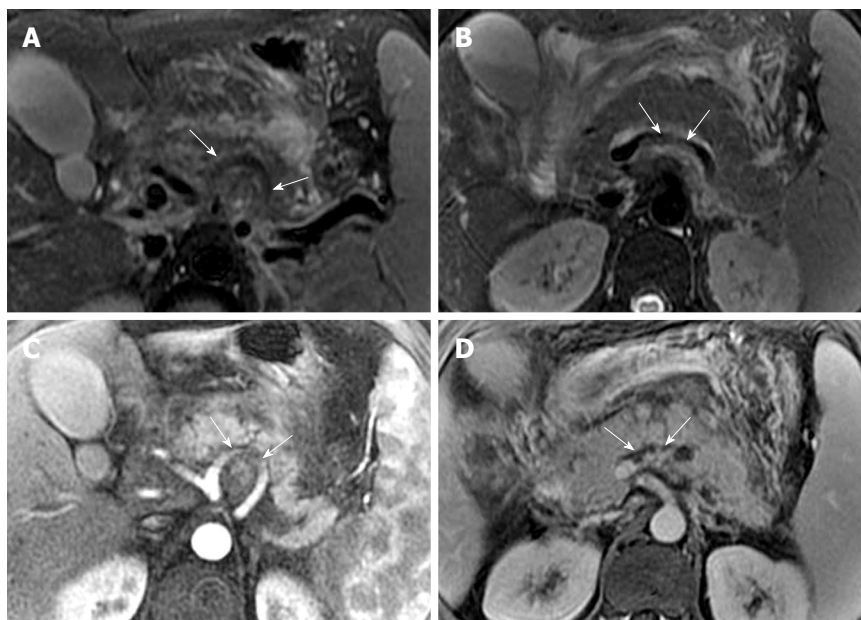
30-year-old man with acute pancreatitis and splenomegaly. Axial T2-weighted images (A and B) show the involved segments (arrows) of splenic artery (A) and splenic vein (B). Enhanced arterial phase (C) and venous phase (D) images reveal clearly the involved segments (arrows) of the splenic artery (C) and vein (D).
